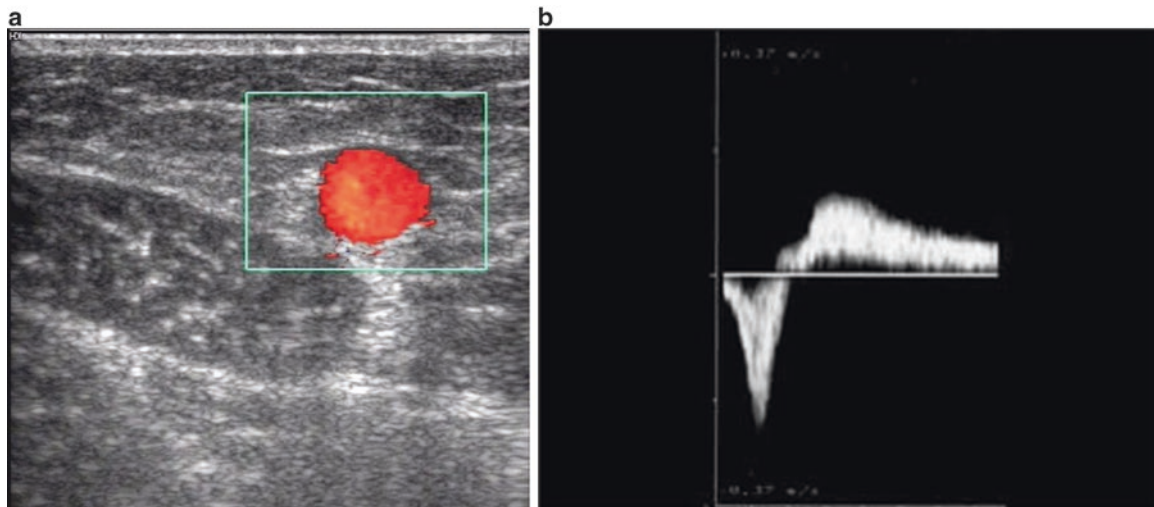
(a) Color Doppler US demonstrating reflux in the GSV. Red color is usually used to indicate reversal of flow. (b) Doppler waveform demonstrating antegrade flow (below horizontal line) followed by reversal of flow with several seconds of reflux (above horizontal line) in the GSV
